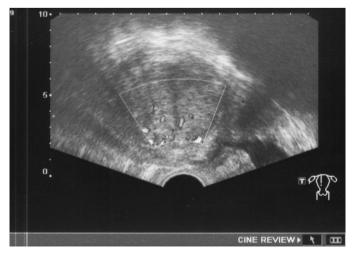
Transvaginal color Doppler ultrasound shows increased central vascularization in the heterogeneous tumor (transverse orientation of the ultrasound probe)
